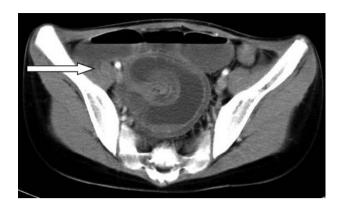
An enhanced computed tomography (CT) scan of the abdomen and pelvis revealed extensively dilated small bowel loops with air fluid levels and a multiple concentric ring sign change of the small bowel. No abdominal mass was found (arrow).
